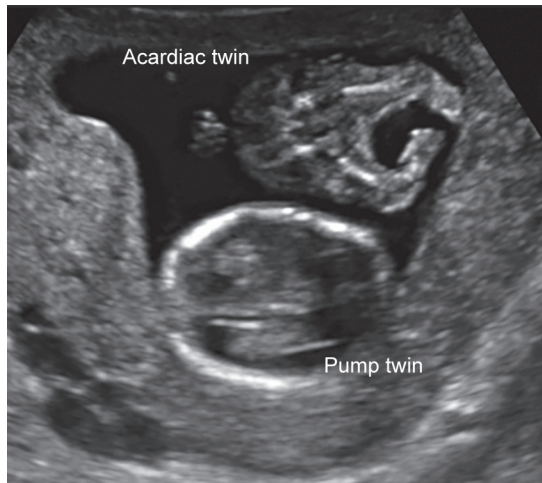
Ultrasound picture of the monozygotic twin pregnancy with TRAP Sequence showing the acardiac twin and the pump Twin
